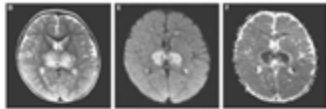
Clinical Example: Acute necrotizing encephalopathy of childhood. Diffuse white matter lesions with ring-like appearance on T2-weighted, and a dot appearance on T1, are seen in this patient.
